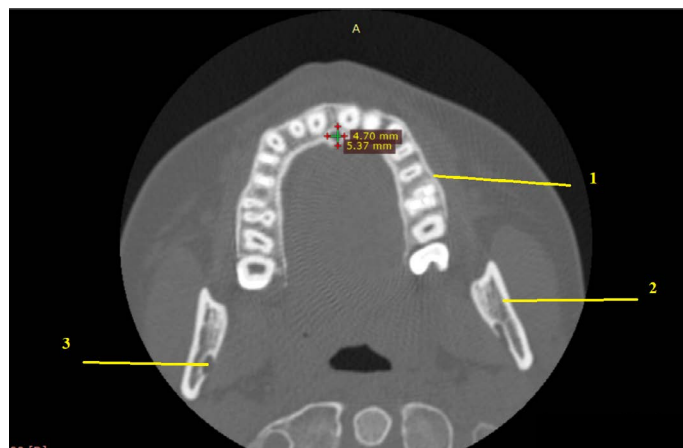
CT Axial Slice. 1 – Alveolar process, 2 – Mandibular arch 3 – Mandibular canal. The dimensions of the incisive canal are indicated by numbers.
